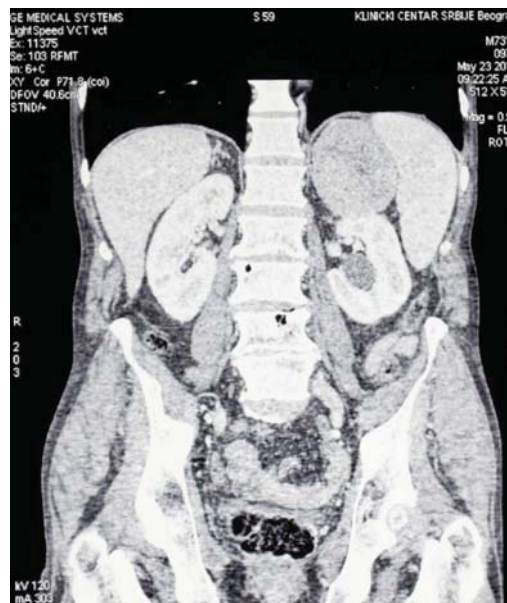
Computed tomography scan of abdomen demonstrated 9 × 7 cm mass of the left adrenal gland.
